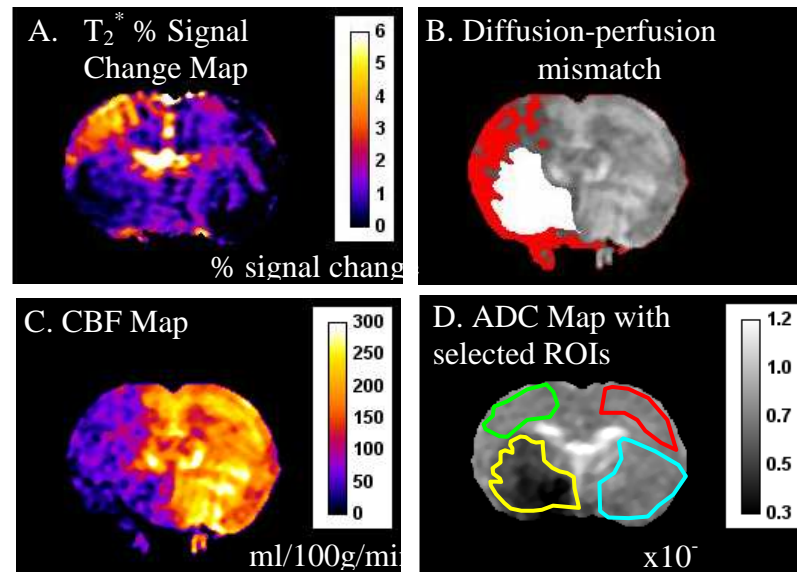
MRI scans used for data analysis. Regions of interest (shown in D) selected from a single MRI slice, where green ROI represents the T_2^* OC defined penumbra (from T_2^* % signal change map (A), the yellow ROI is the ADC-derived ischaemic core (from the ADC map), and the red and sky blue ROIs are the contralateral cortex and caudate, respectively. Penumbra defined from diffusion-perfusion mismatch is included for comparison (B)
